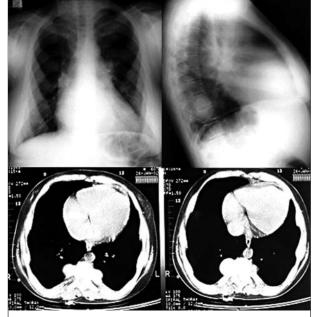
A mass shadow and widening of the ribs were seen in the posterior-anterior chest X-ray of our patient
